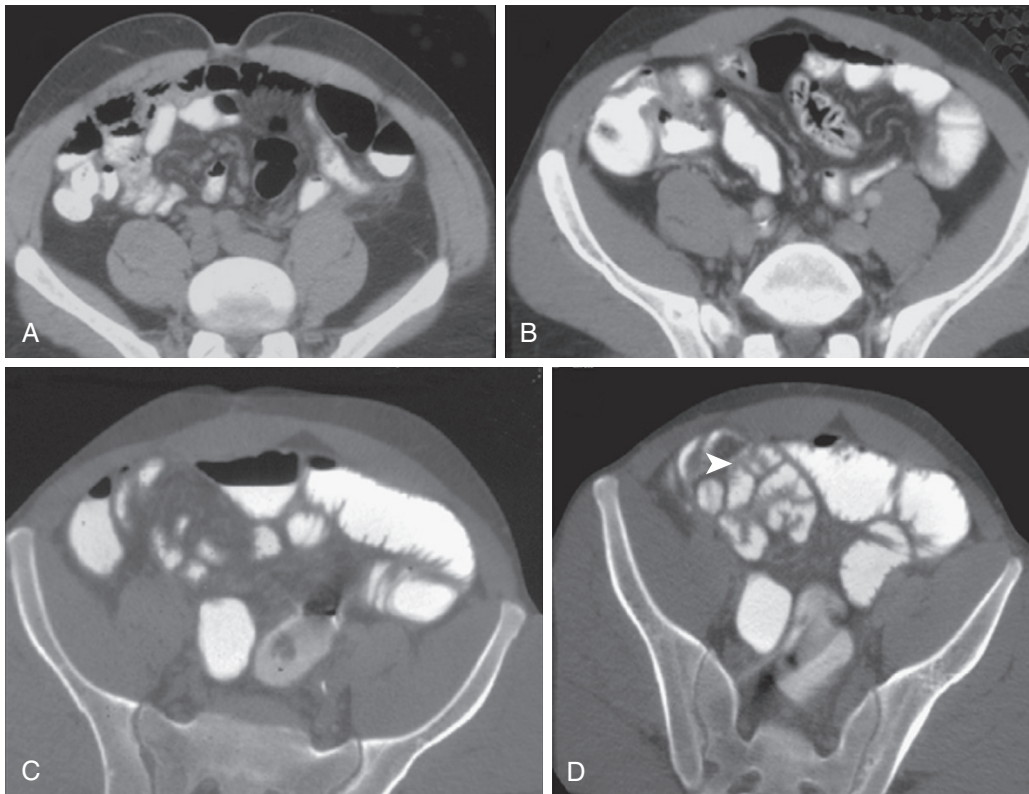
Conventional CT and CTE in low-grade small bowel obstruction. A, B. There is no evidence of a gradient or transition point to suggest mechanical obstruction in a patient with symptoms of recurrent SBO. C, D. CTE of the same patient demonstrates the transition point and prestenotic dilation from an anterior parietal adhesive obstruction posterior to the right rectus muscle. Interloop (visceral) adhesions (arrowhead) are noted in segments posterior to the parietal adhesive obstruction.
